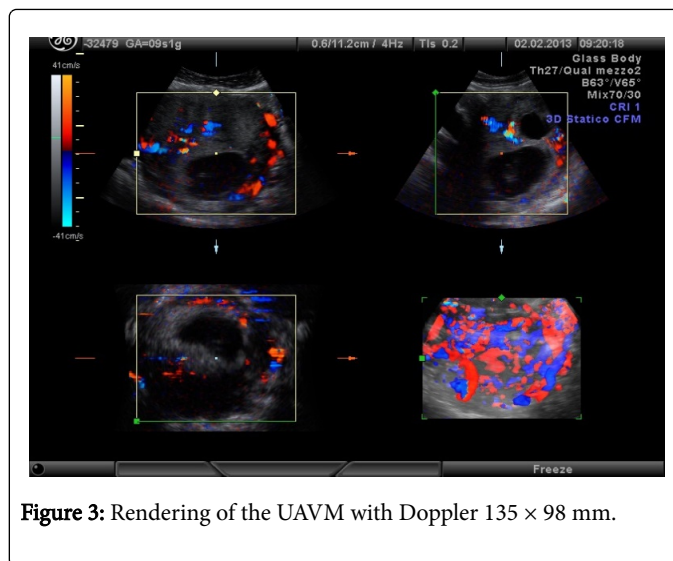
Rendering of the UAVM with Doppler 135 x 98 mm.
